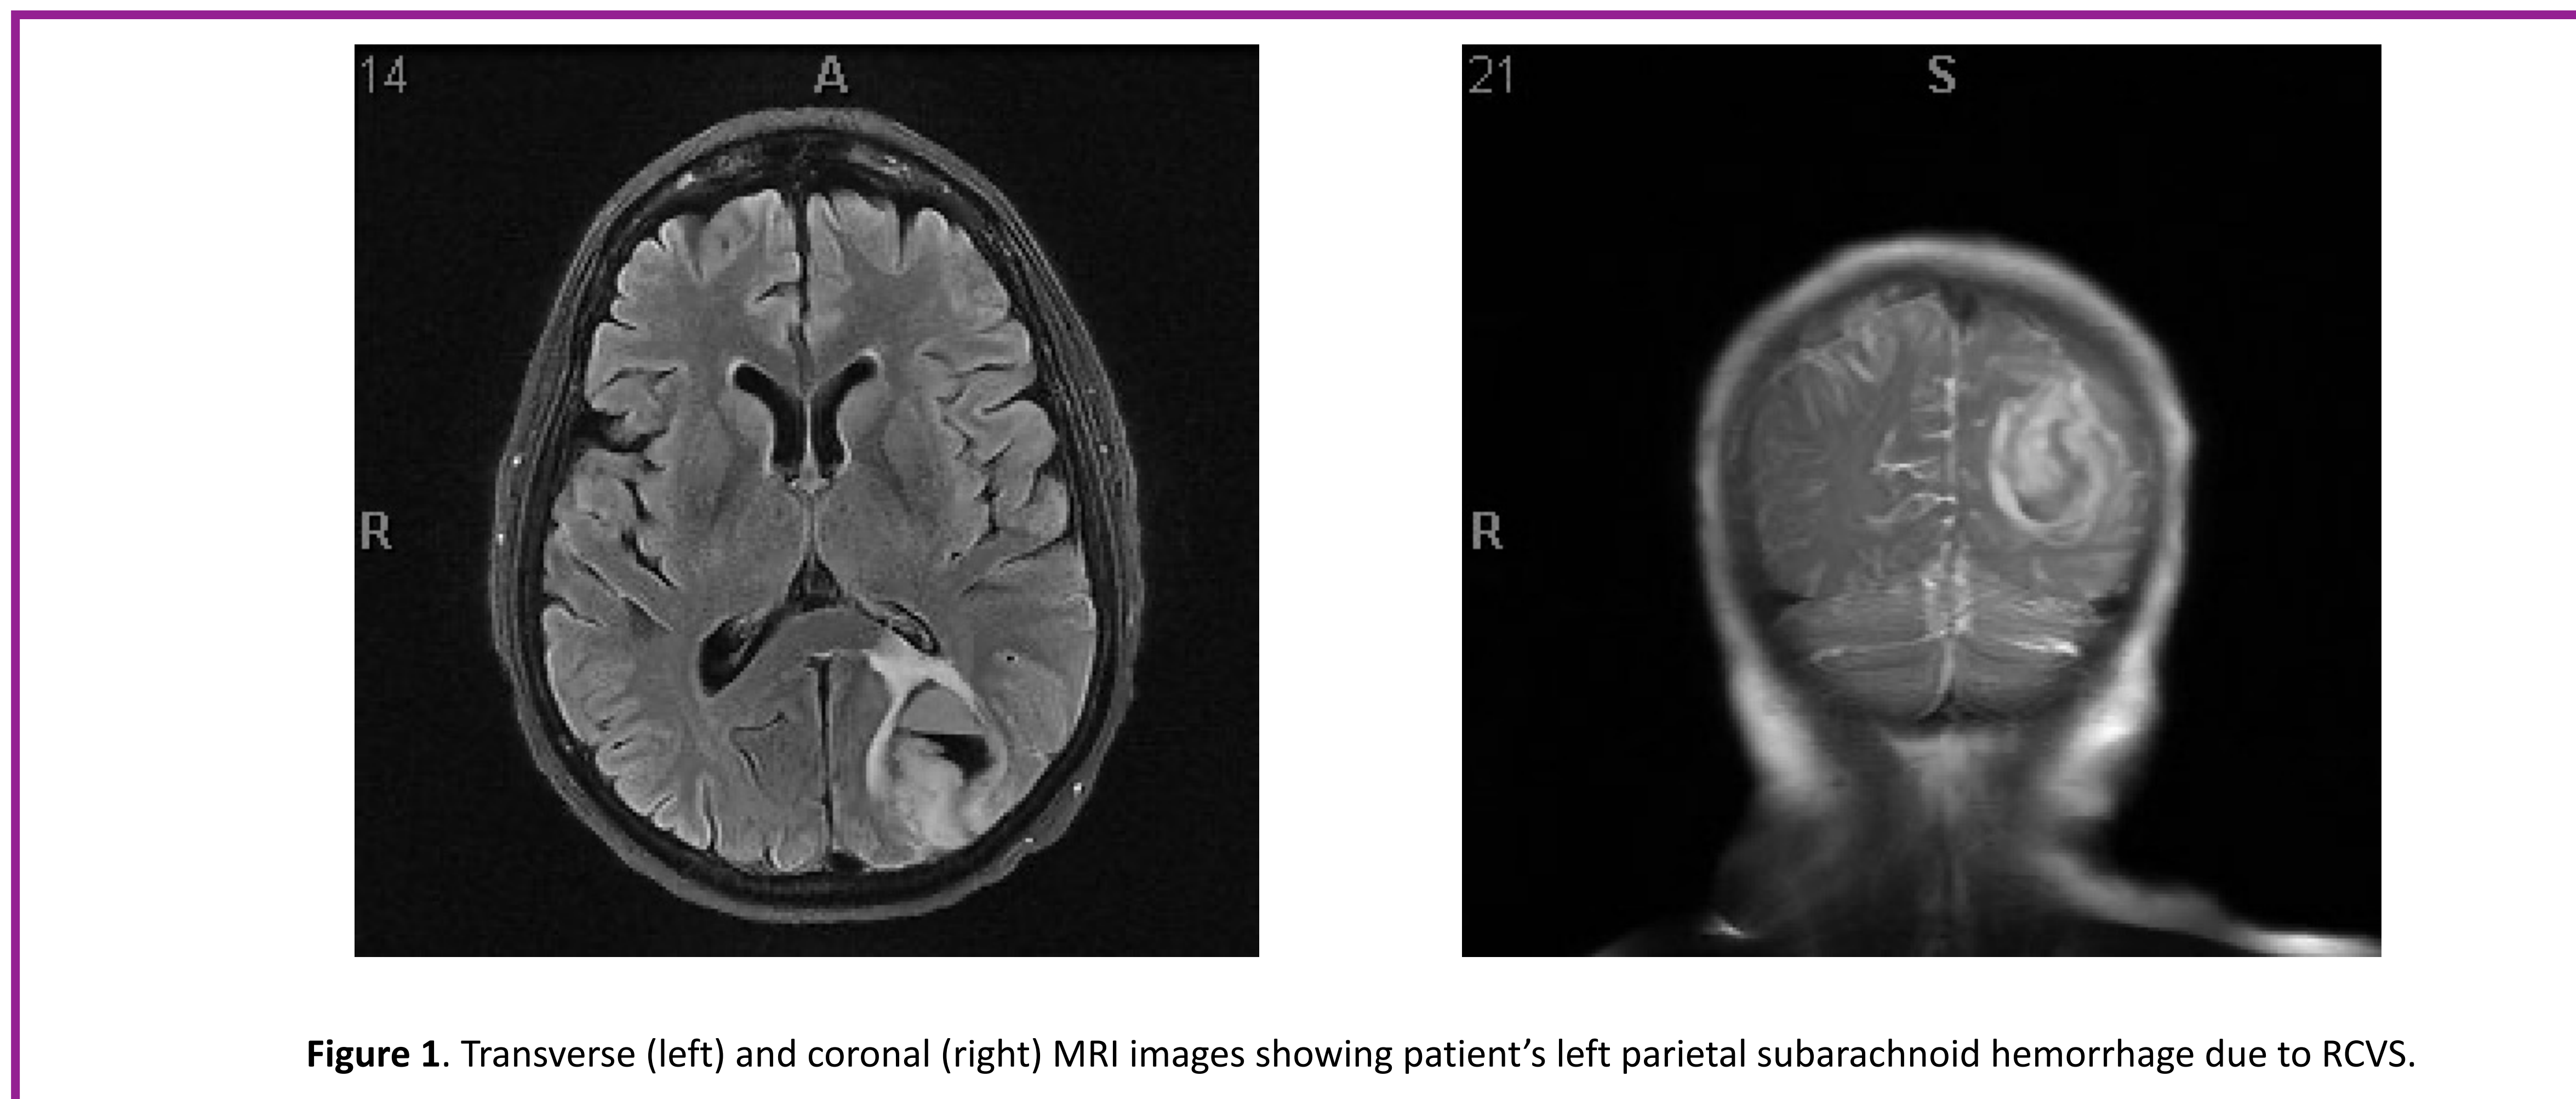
Transverse (left) and coronal (right) MRI images showing patient's left parietal subarachnoid hemorrhage due to RCVS.
